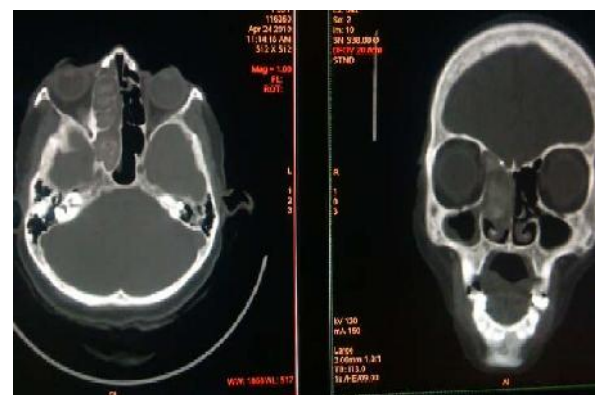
(a) Soft tissue attenuating lesion occupying the right maxillary and right ethmoid sinus with central hyperattenuating areas seen. (b) Ballooning of lamina papyracea seen secondary to mass effect with Right orbital proptosis with preseptal swelling seen – CT Features are typical of FUNGAL SINUSITIS
